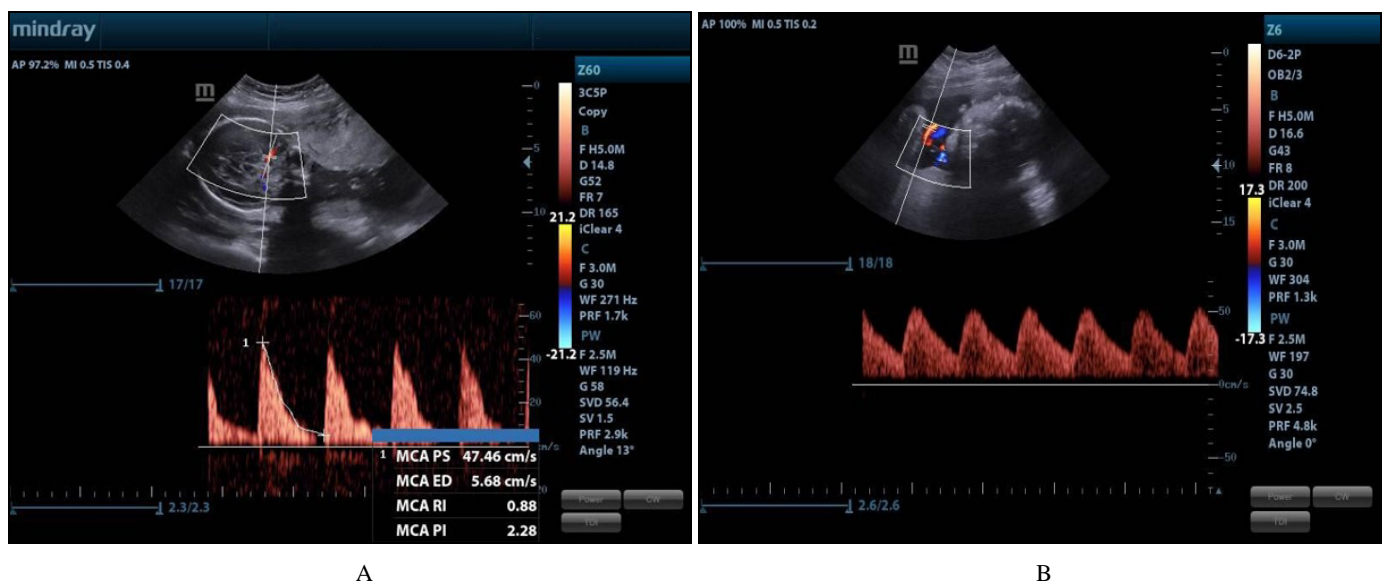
Doppler of (A) middle cerebral artery pulsatility index measurement (MCA PI) and (B) umbilical artery (UA) in 38 week of gestation in normotensive patients
